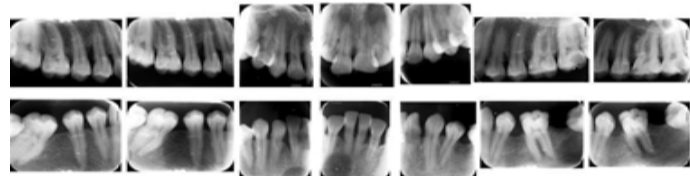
Full mouth radiographs demonstrating generalized severe vertical bone loss and tooth extraction.
